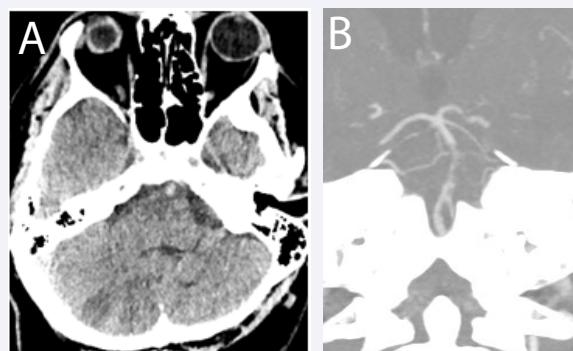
Control native CT (A) angiography (B) showing reocclusion of the basilar artery and with ischemia of the cerebellum and mesencephalon.
